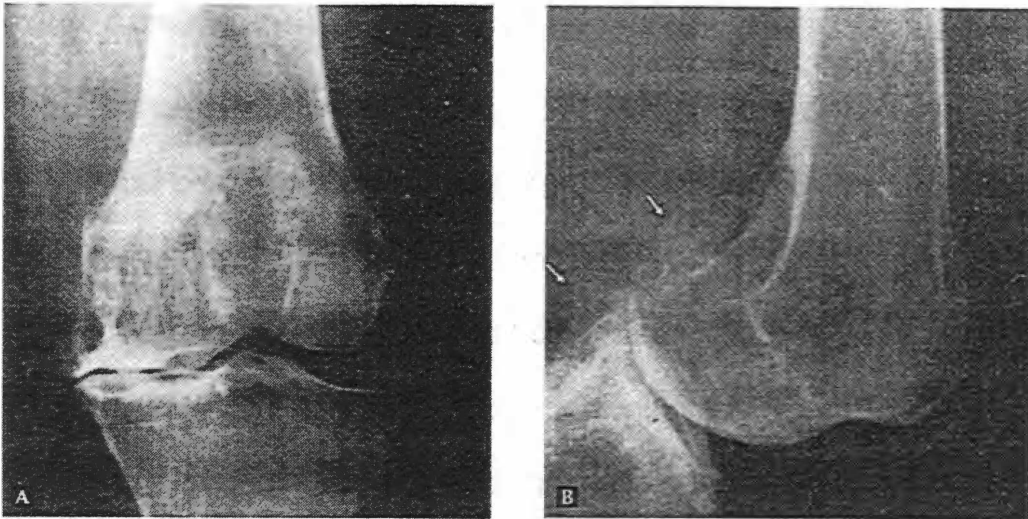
Radiographs of (A), The anteroposterior and (B), The lateral views of an osteoarthritic knee demonstrate joint space narrowing, osteophyte formation (*arrows*), and bony sclerosis. Reproduced from McCarty, 1989.
